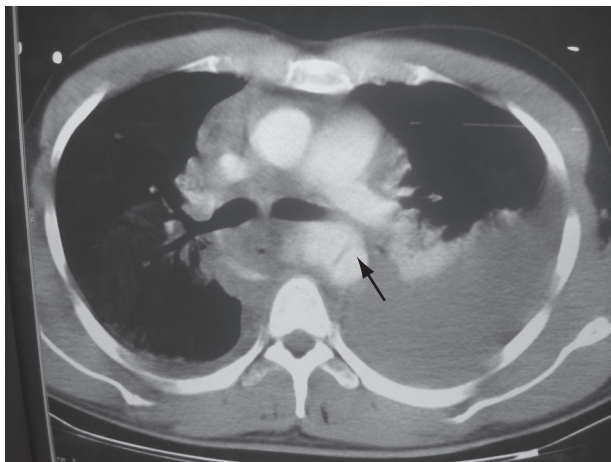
Chest computed tomography (CT) scan demonstrating periaortic hemorrhage and an intimal flap (arrow).
